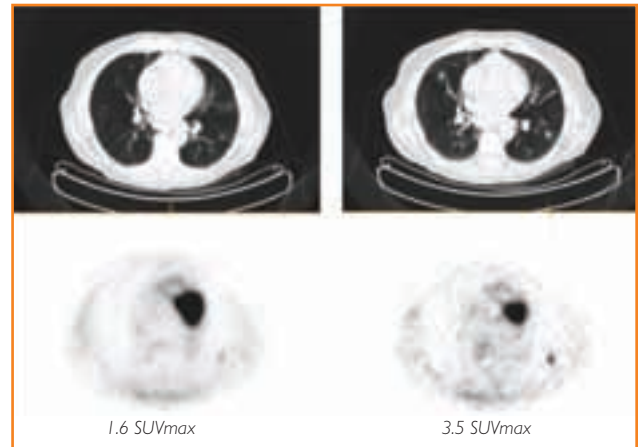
Comparison of TOF PET/CT images of small pulmonary nodule acquired without (left) and with (right) respiratory gating. (Source: Benard F, et al.¹²)
